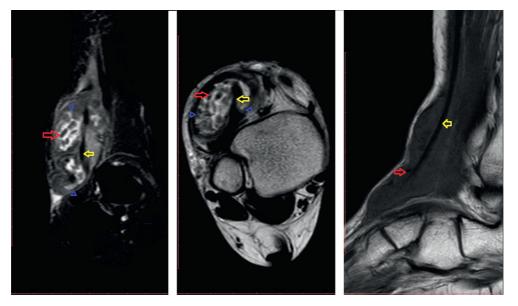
MRI shows the hypointense rice bodies (red arrow) on T2 weighted (first two panels) and T1 weighted image (third panel). Between the blue arrowheads is the clear hyperintense fluid contained in a well-defined dumbbell shaped pocket around the extensor digitorum tendon (yellow arrow) with normal signal intensity of the tendon.
